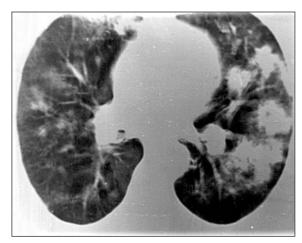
At the time of initial presentation, CT showed bilateral patchy consolidation and nodules.
